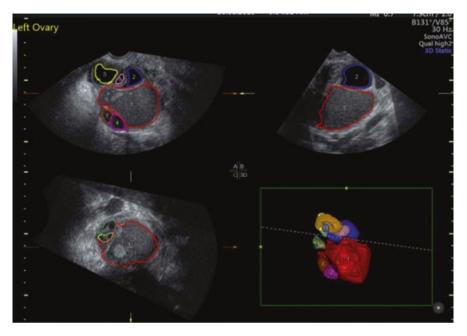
Ultrasonographic view of an ovarian endometrioma during ovarian stimulation
